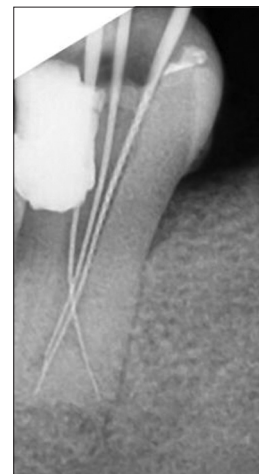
Radiograph for working length determination
